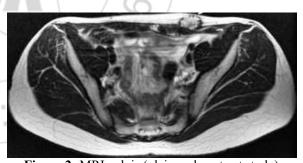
MRI pelvis (plain and contrast study)
